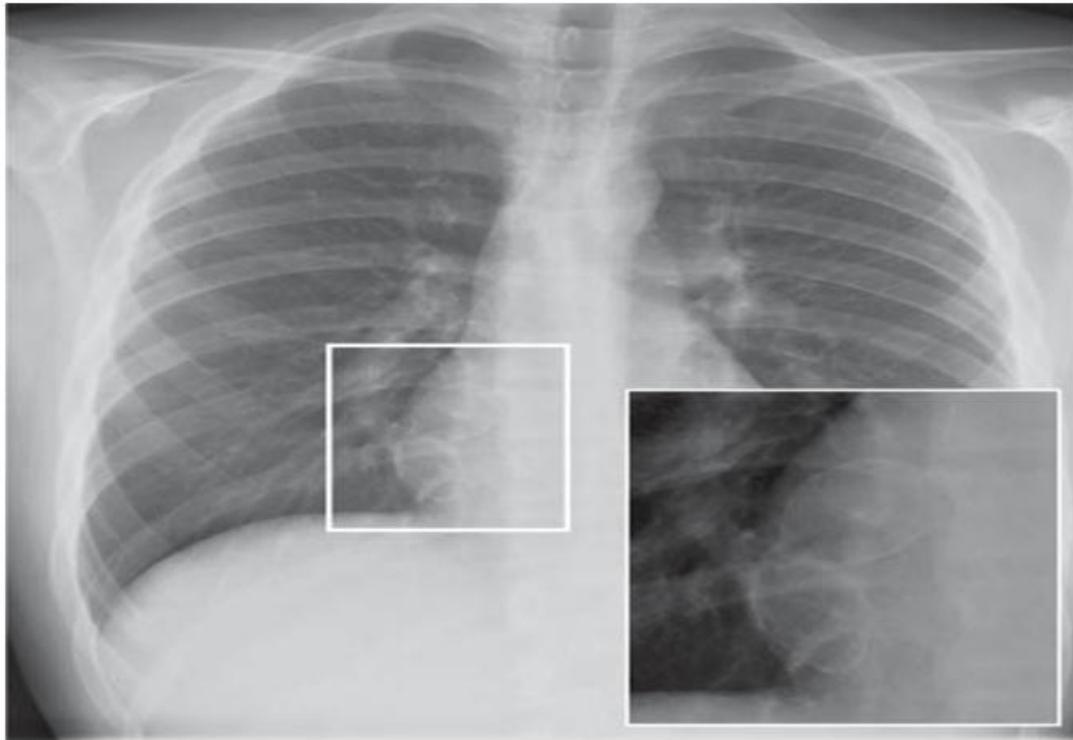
Chest X-ray showing enlarged in heart in child with Kawasaki disease.
